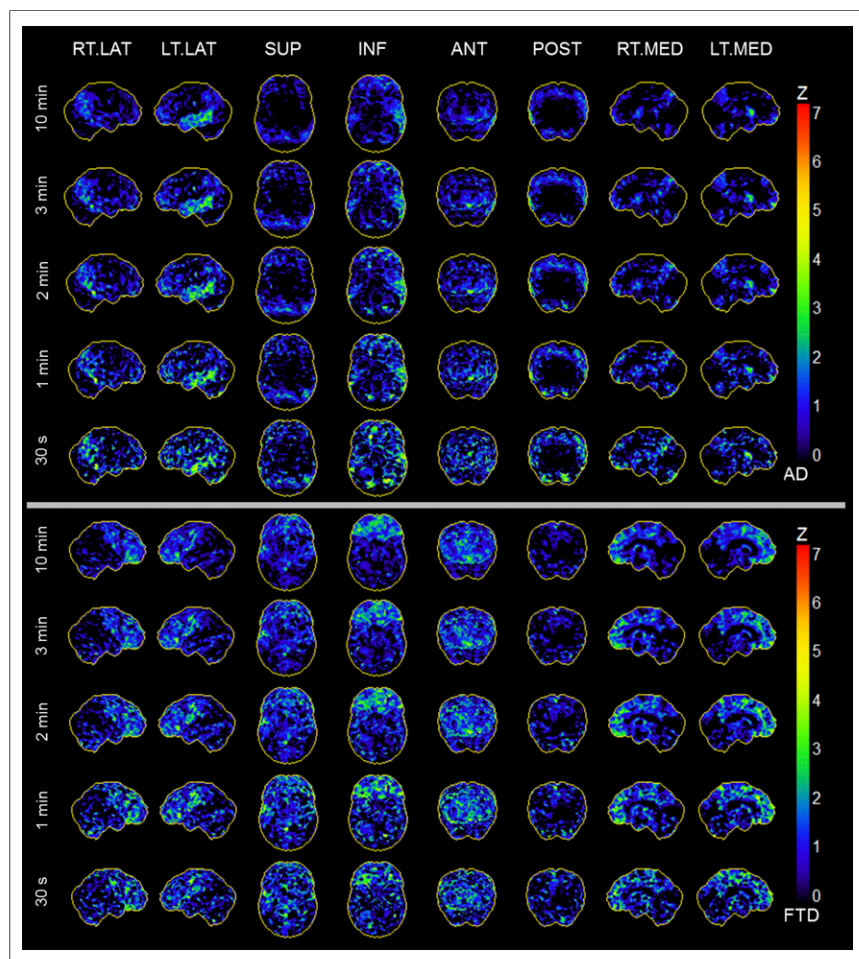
Results of Neurostat 3DSSP analysis as used for clinical evaluation of AD patient 4 and FTD patient 25: decrease in regional ^{18}F -FDG uptake normalized to cerebellum and color-coded as z score. Effect of reduced acquisition time is presented starting from standard duration of 10 min down to 30 s.
